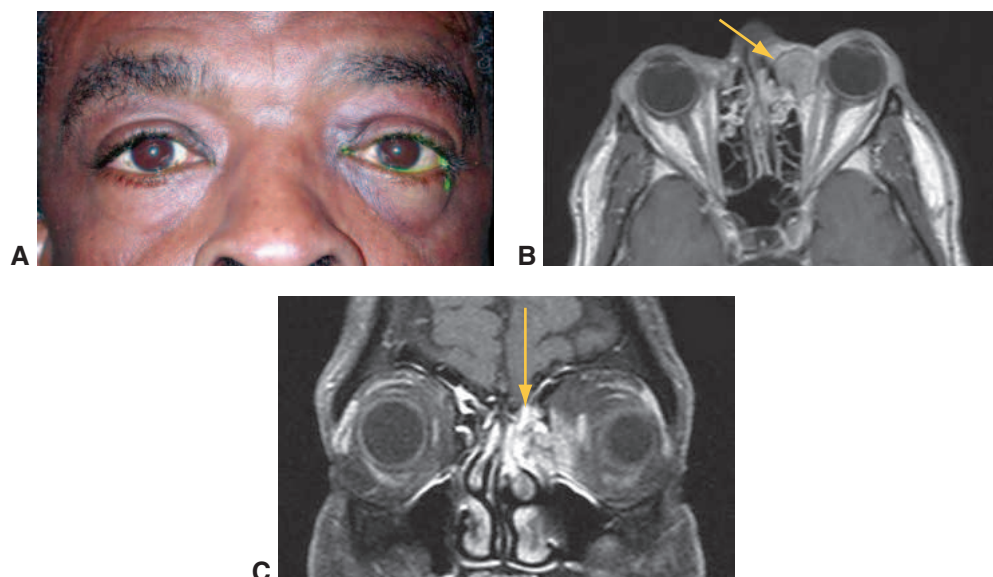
Ethmoid sinus squamous cell carcinoma. A, Photograph shows fullness of the medial canthal area overlying the mass. Axial (B) and coronal (C) T1-weighted MRI with gadolinium contrast reveals a mass in the ethmoid sinus eroding into the medial orbit (arrows). (Courtesy of Julian D. Perry, MD, and Alexander D. Blandford, MD.)
